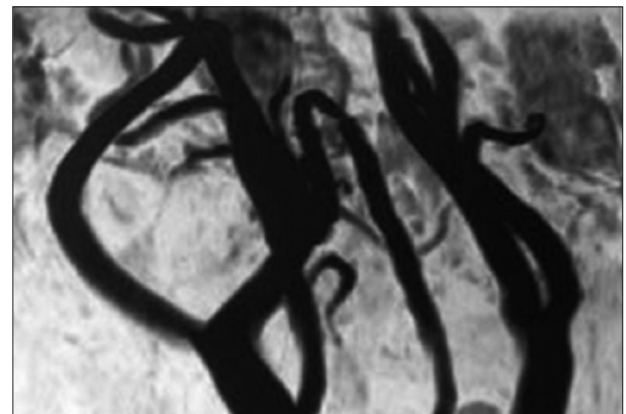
Cervical MRI confirming the presence of a carotid body tumor
